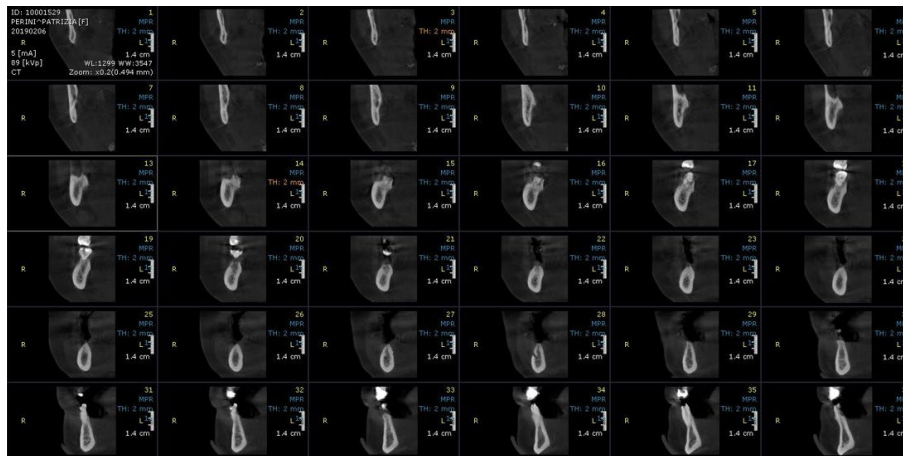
TC Cone Beam pre-surgical site, sections of the posterior mandible.
